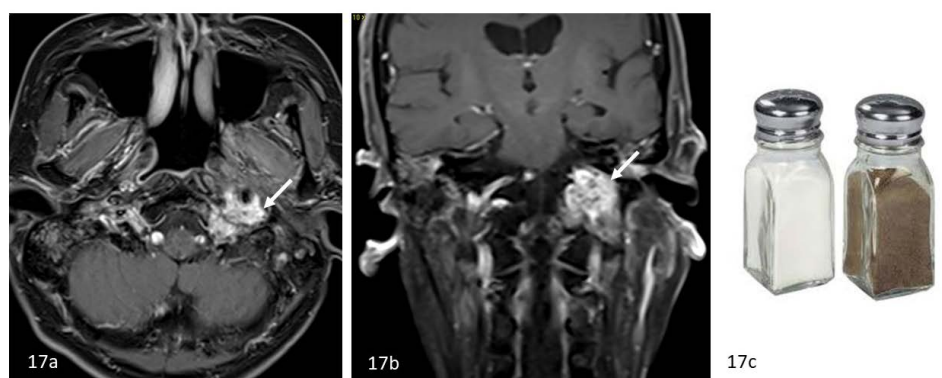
Salt and pepper sign. 62 year old male with a jugular paraganglioma. Axial (17a) and coronal (17b) contrast enhanced T1-weighted images shows an avidly enhancing mass with characteristic salt-and-pepper speckled appearance in the left jugular foramen with multiple areas of signal voids (white arrows), suggestive of a jugular paraganglioma. There is adjacent bony erosion and encasement of the left internal carotid artery. (17c) Image of table salt and pepper. Siemens Aera (1.5 Tesla, Slice width 5.0 mm, Axial: TR 625 TE 11 FA 146, Coronal: TR 691 TE 8.6 FA 150. Intravenous contrast: 10 ml Dotarem.
